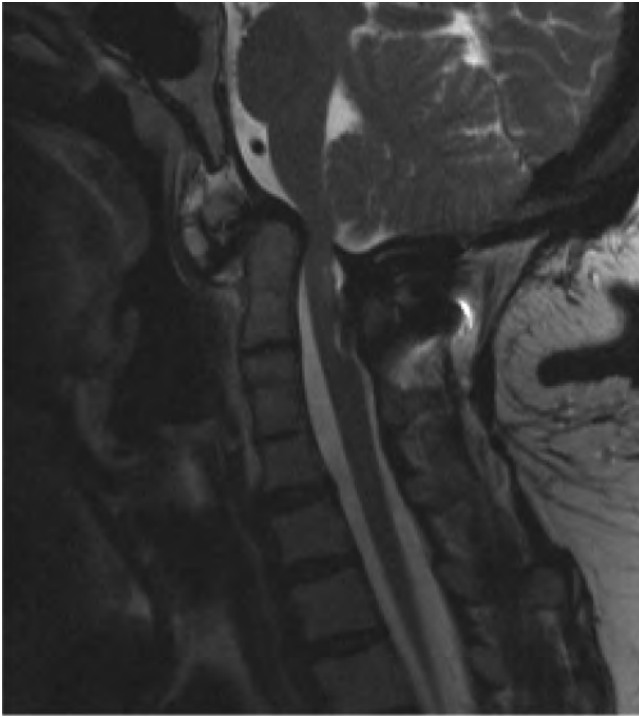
Congenital basal impression. Odontoid peg compression at cranio-cervical junction (MRI T2W).
